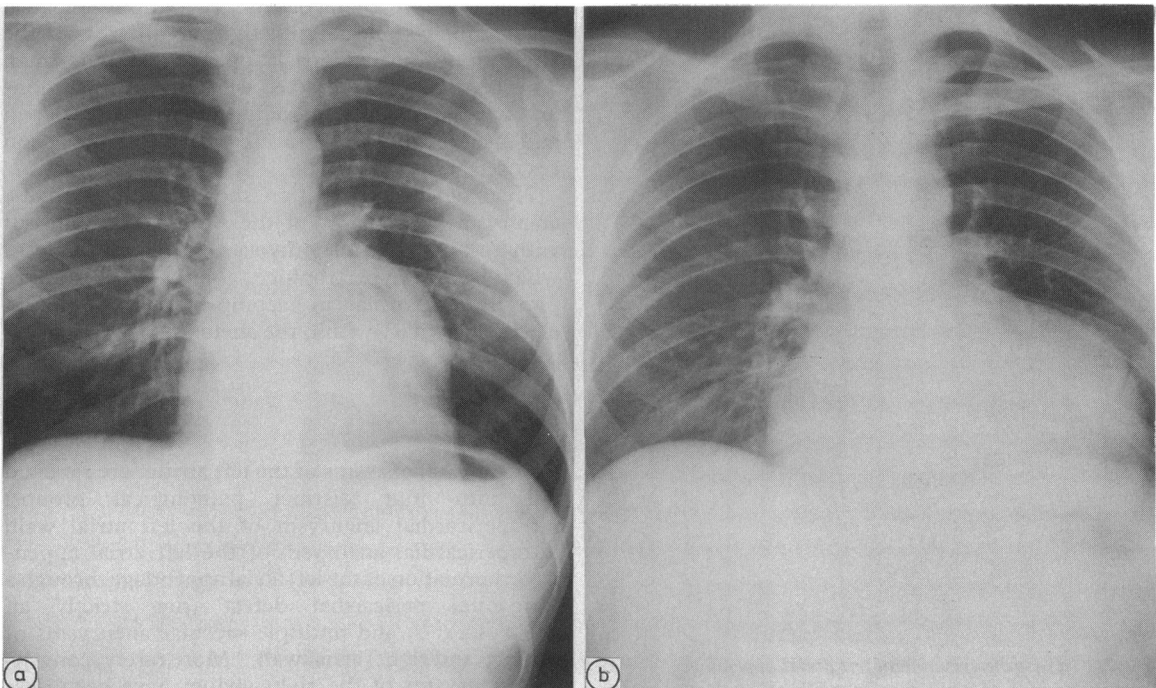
(a) Chest radiograph showing an abnormally prominent left heart ten years before presentation. (b) Chest radiograph showing cardiomegaly at presentation.
